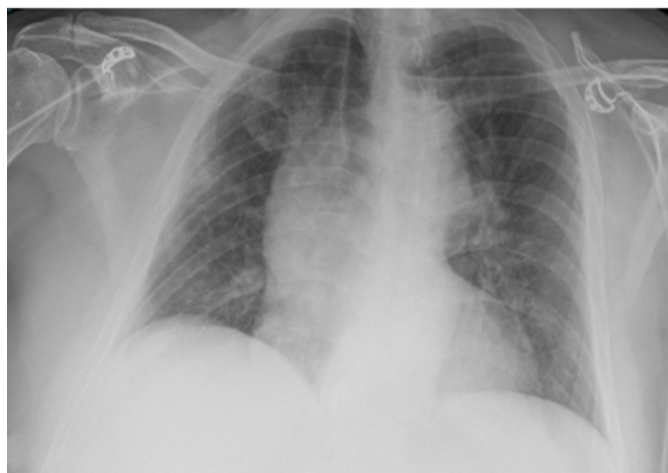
Plain chest X-ray showing bi-basal opacification.
